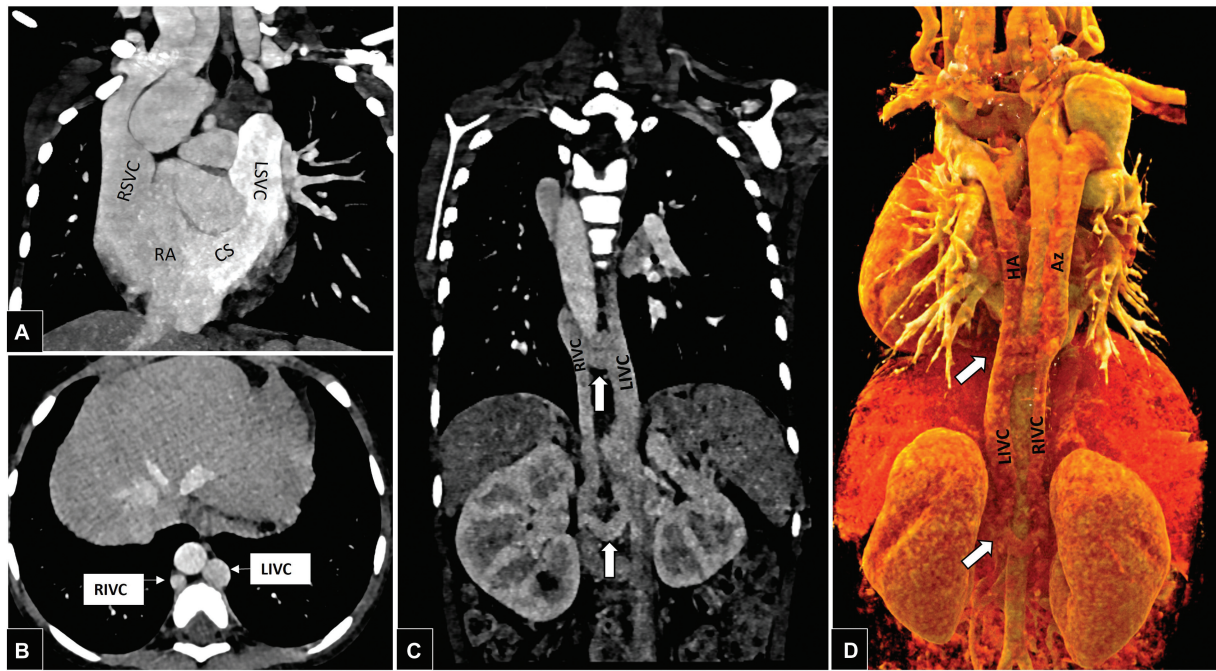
(A) Coronal computed tomography (CT) image showing the drainage of the left superior vena cava (LSVC) through the coronary sinus (CS) into the right atrium (RA). The right superior vena cava (RSVC) was draining normally into the RA. (B) Axial image just above the diaphragm shows complete duplication of the IVC with the smaller right-sided IVC and larger left-sided IVC coursing along either side of the aorta. (C) Coronal maximum intensity projection and (D) virtual reconstructed image showing the supra-diaphragmatic continuation of RSVC and LSVC as the azygos (Az) and hemiazygos (HA) veins, respectively, with arrows depicting the communications between them. LIVC, left inferior vena cava; RIVC, right inferior vena cava.
